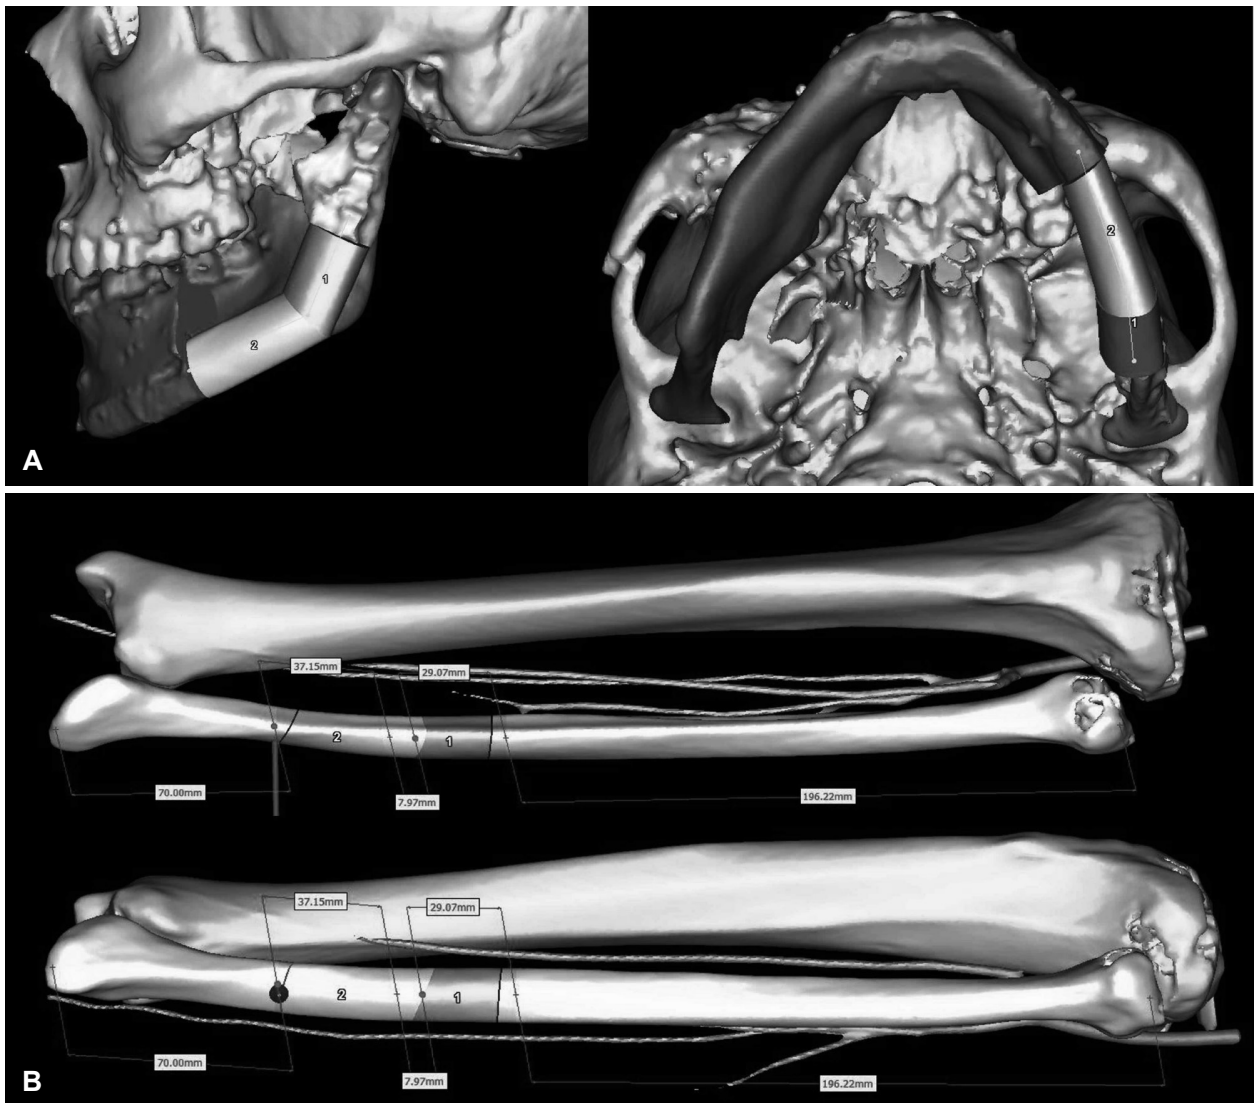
Three-dimensional virtual planning. A: Virtually reconstructed mandible with fibula free flap. B: Position, length, angle of osteotomy within fibula were planned on patient's three-dimensional computed tomography of left lower leg.
